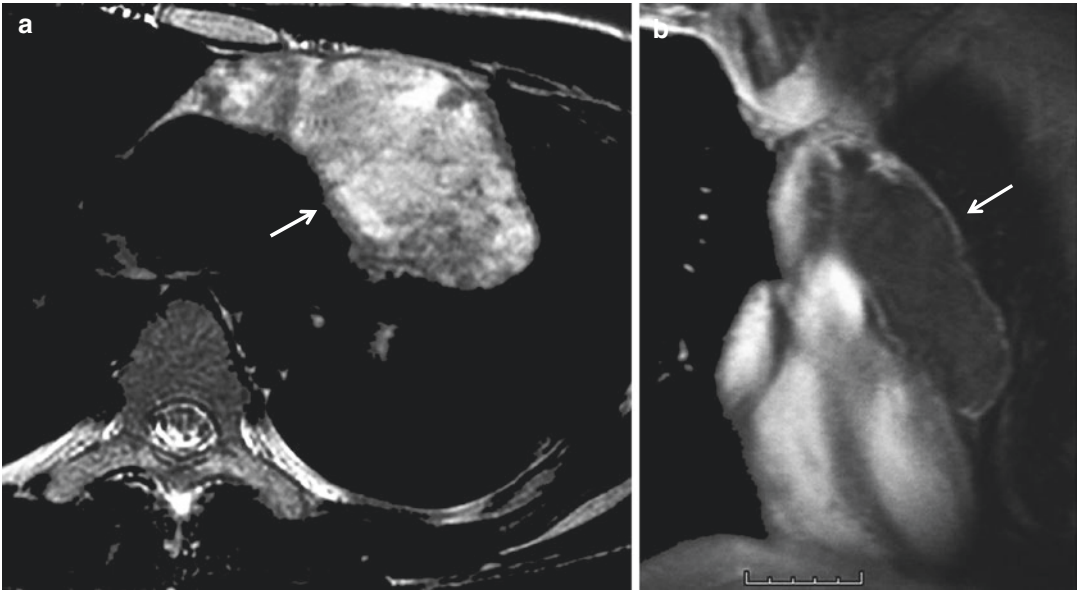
Non-seminomatous malignant germ cell tumor. (a) T2-weighted axial image typically shows heterogeneous signal intensity with areas of low, intermediate, and high signal intensity (*arrow*). (b) Contrast-enhanced
